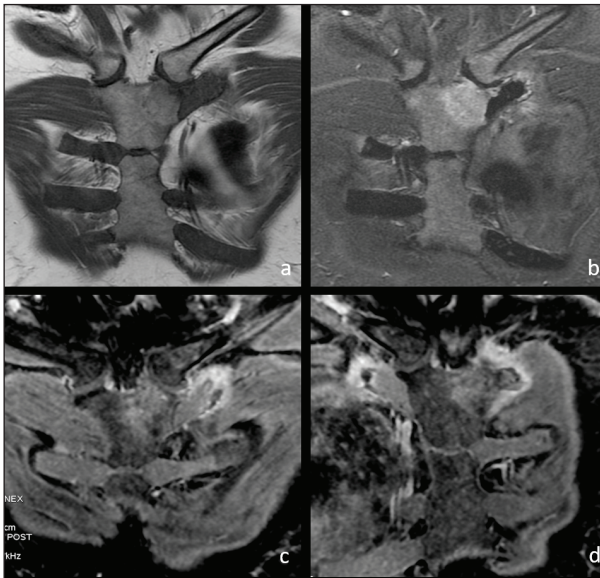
MRI examination of a 38y old female with psoriasis and pain and swelling of the left SCJ. She told the same symptoms a few years earlier, at the contralateral SCJ. MRI showed fat deposition (T1 weighted image, a) and marrow edema (T2 weighted image, b) of the subchondral bone of the manubrium and signs of enthesitis on the costochondral cartilage of the first rib and on the inner portion of the end of the clavicle (T2 weighted image, b, and T1 gradient echo image with fat saturation after contrast media administration, c and d). Signs of enthesitis were also present on the costochondral cartilage of the first rib on the right side (d). The MRI diagnosis, confirmed by clinical and laboratory data, was AWC involvement in psoriatic arthritis.
